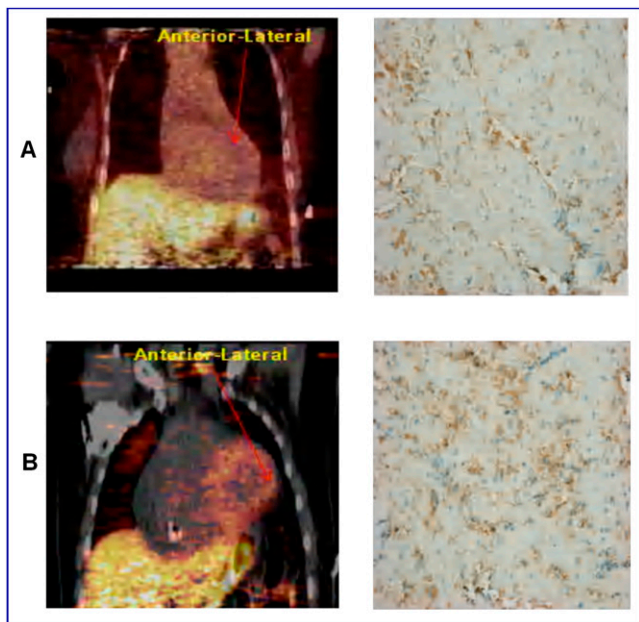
Cardiac iNOS PET/CT imaging using ^{18}F -NOS.
